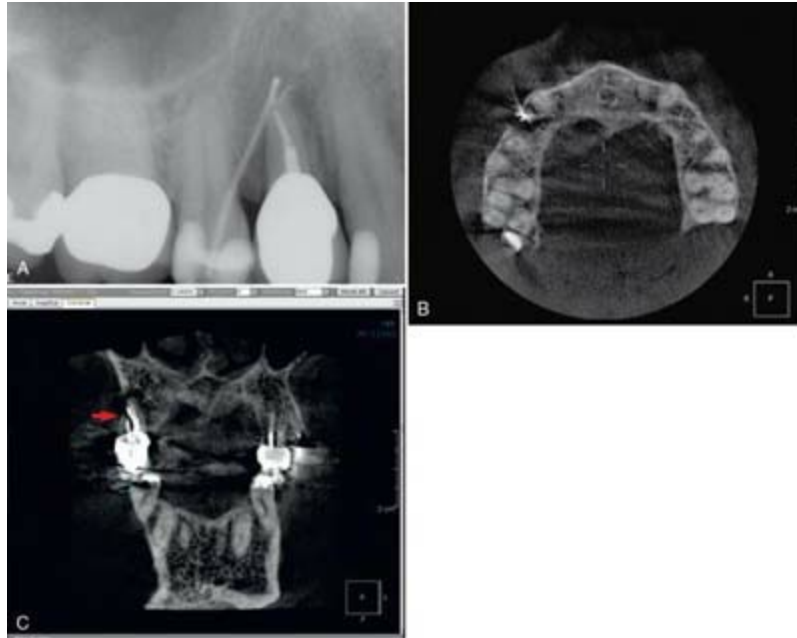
A, Periapical radiograph with gutta-percha tracing the sinus tract to tooth #5. Periodontal probings were within normal limits. This tooth was initially referred for exploratory surgery to rule out root fracture. CBCT confirmed root fracture and the treatment plan was changed to extraction with possible bone graft and guided tissue regeneration for ridge augmentation prior to implant placement. B, Axial CBCT view demonstrating extent of lesion. C, Coronal CBCT view demonstrating root fracture (*red arrow*) and perforation of buccal cortical plate in area of root fracture but intact bone in the cervical area.
